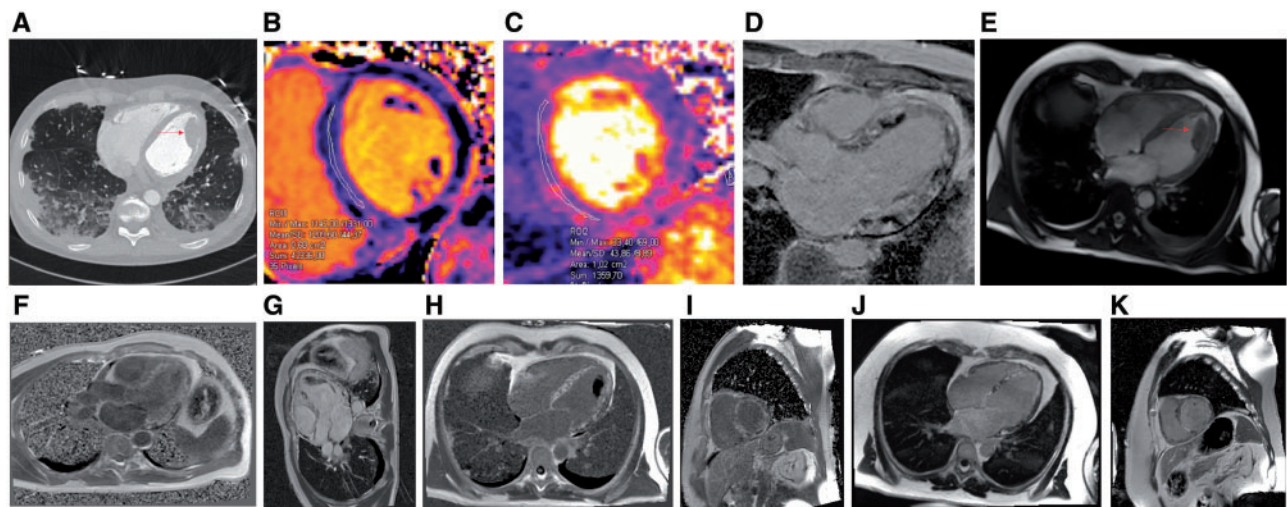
(A) Thoracic CT showing bilateral, patchy peripheral ground-glass opacities with a crazy-paving pattern, focal consolidations, and mild pleural effusions. There is also a large thrombus in the left ventricle (arrow). (B) Cardiac MRI: T1 mapping with a prolonged global native T1 time of 1209 ms (cut-off 1170 ms at 3T). (C) Cardiac MRI: T2 mapping with a prolonged global T2 time of 44 ms (cut-off 41 ms at 3T). (D) Cardiac MRI; phase-sensitive inversion recovery gradient echo imaging (PSIR) showing extensive late gadolinium enhancement (LGE) of the entire left ventricular myocardium, with dark foci probably representing areas of microvascular obstruction (MVO). (E) Cardiac MRI: cine retro sequence with four-chamber view revealing a large thrombus in the left ventricle (arrow). (F) Cardiac MRI: three-chamber view, PSIR. (G) Cardiac MRI: three-chamber view, PSIR, with TI 600 revealing thrombi. (H) Cardiac MRI: four-chamber view, PSIR. (I) Cardiac MRI; basal short axis: PSIR. (J) Cardiac MRI; four-chamber view, PSIR, follow-up, generalized LGE and areas of MVO have resolved; LGE is condensed; (K) Cardiac MRI: basal short axis, LGE, follow-up.
